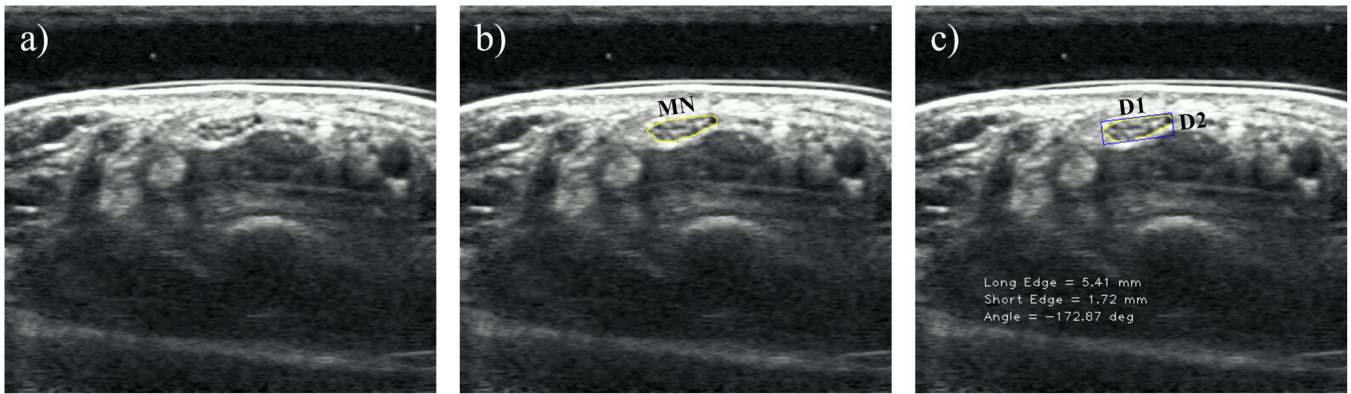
Ultrasound images in this study: (a) original ultrasound image; (b) outline traced by ImageJ; (c) minimum bounding rectangle quantified by Python.
